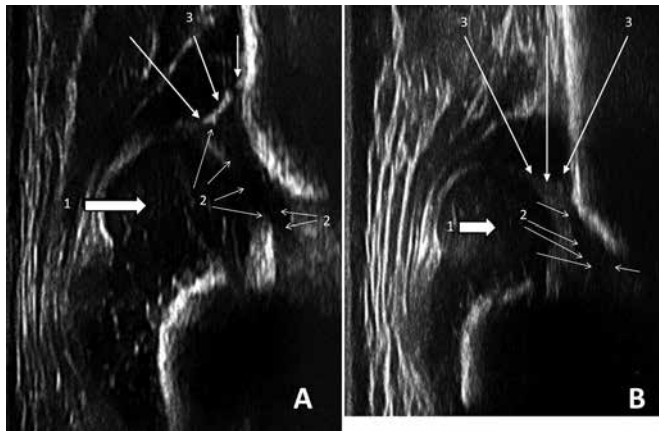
Sonograms showing displaced femoral heads (1) the deformed hyaline cartilage roof is marked (2) as well as the perichondrium (3). (A) Type III, (B) Type IV.
